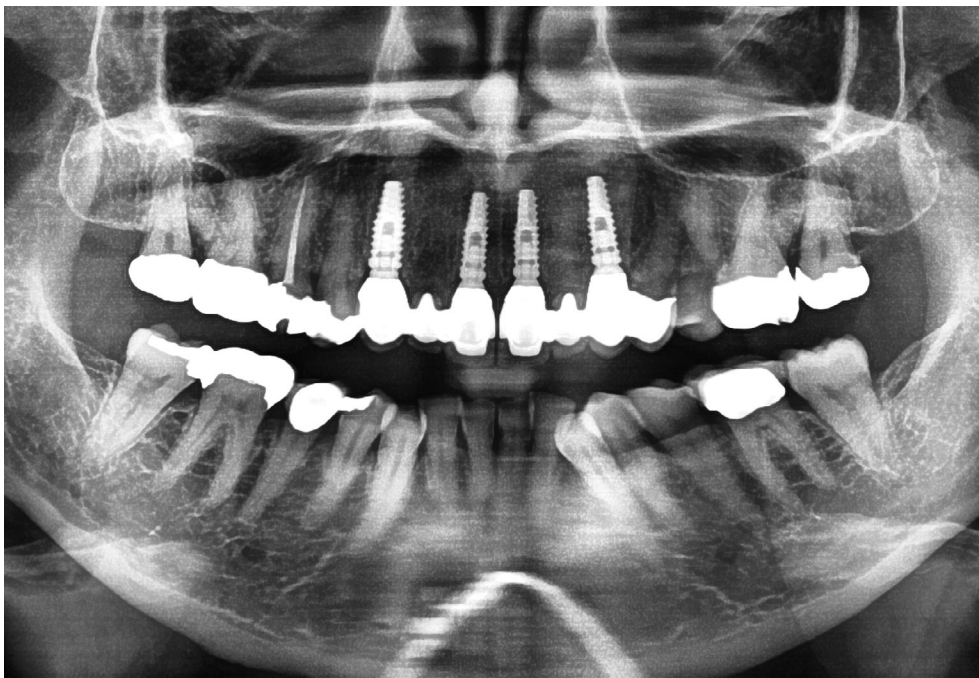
Panorex radiograph at 4 years follow-up
